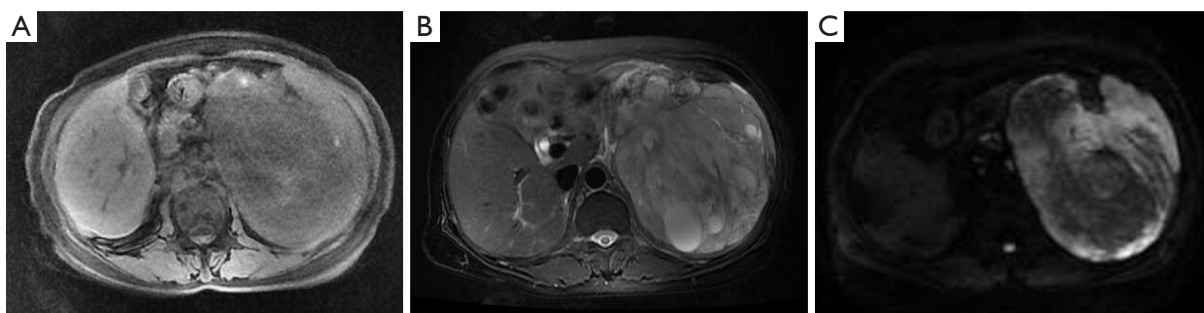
The splenic magnetic resonance imaging (MRI) revealed a giant focus of the posterior peritoneum showing iso-hypointense on T1WI (A), hyperintense on T2WI (B), uneven hyperintense or hypointense on DWI and progressive uneven enhancement in enhancement period (C). DWI, diffusion weighted imaging.
